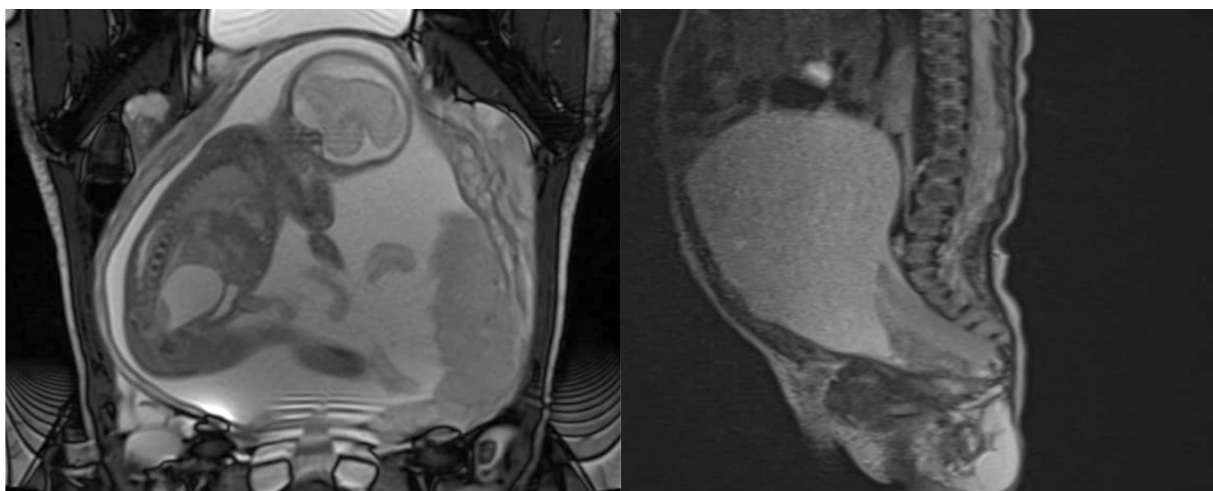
Intrauterine and postnatal magnetic resonance imaging (MRI) findings of a sacrococcygeal teratoma
